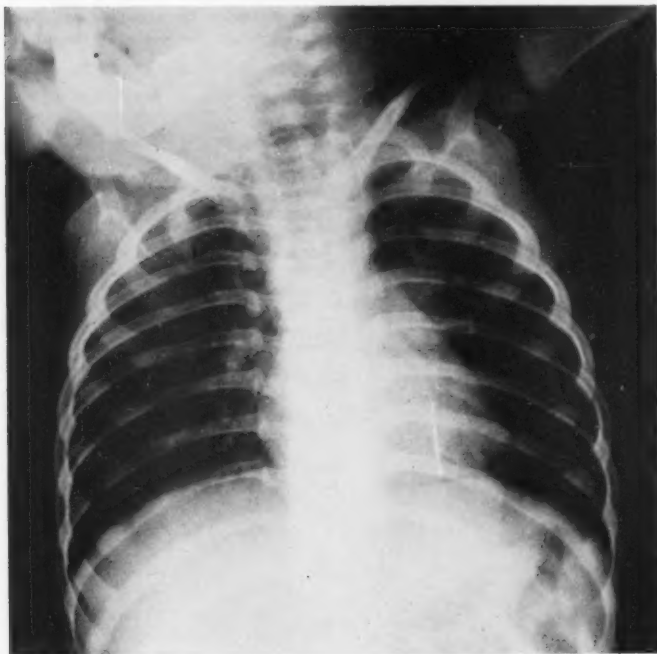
Postero-anterior roentgenogram showing straight pin, head down, in the posterior basal segment of the left lower lobe.
